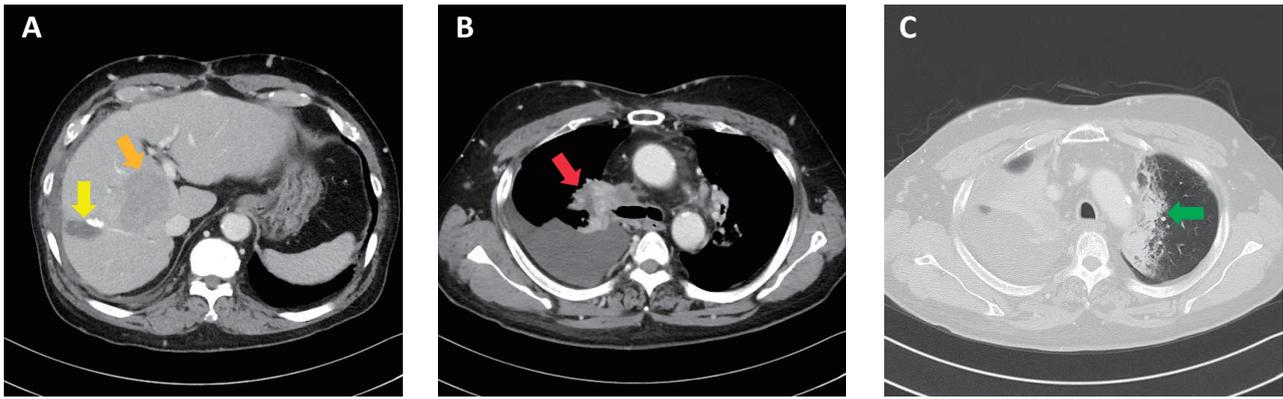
Computed tomography images on admission.
